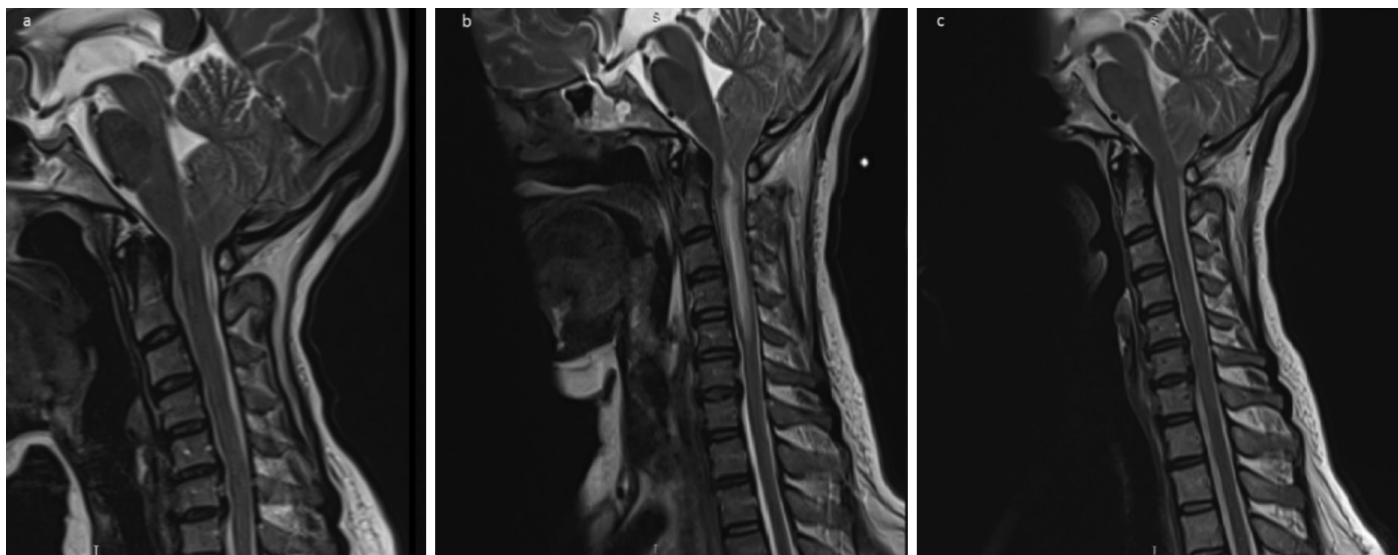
Enhanced craniocervical magnetic resonance imaging images. a) The magnetic resonance imaging (MRI) image of the patient recorded at the time of the first admission. b) The MRI image recorded on the third day of follow-up. Myelitis at the level of cervical cord (C2-C6). c) The MRI image recorded after three weeks of treatment
